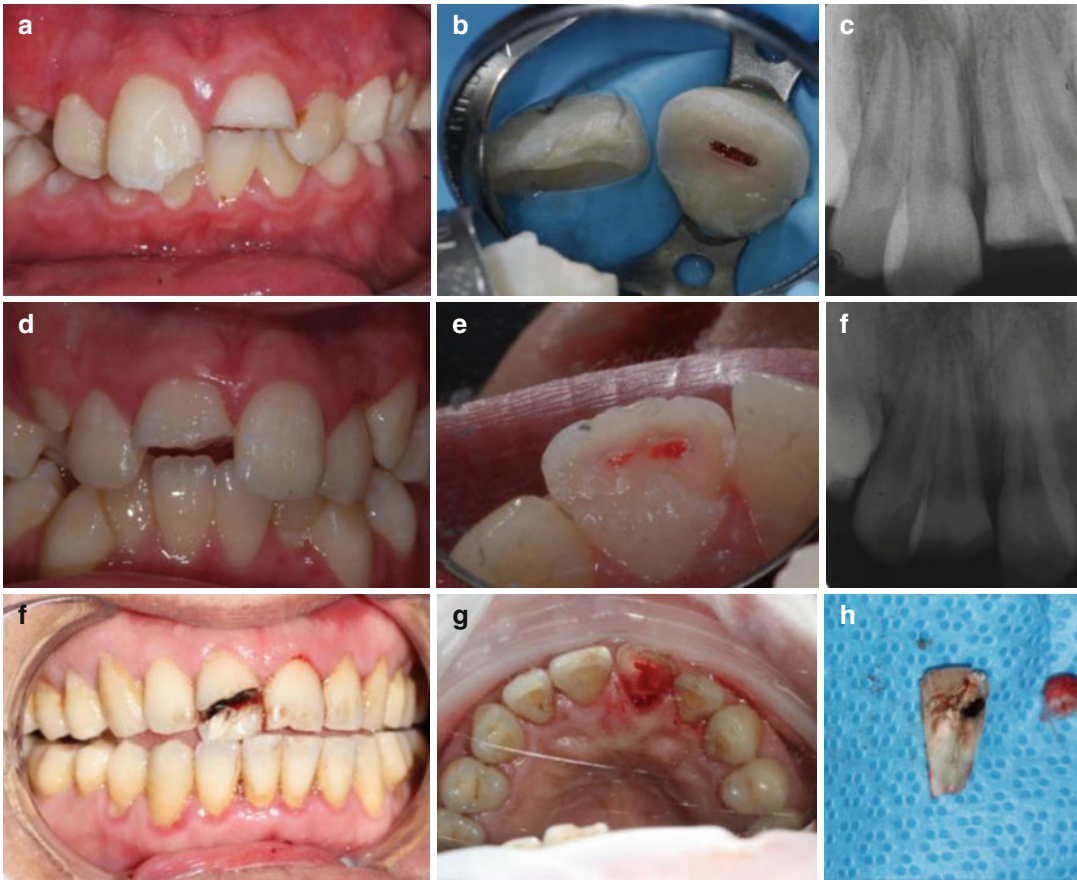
Clinical photographs and radiographs demonstrating complicated crown fractures (enamel-dentine-pulp injuries). Note: (a–c) complicated crown fracture affecting tooth
